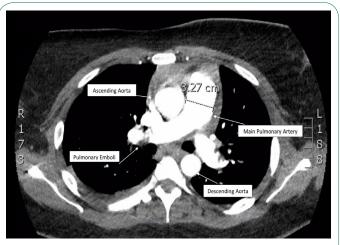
CT chest angiogram confirmed diagnosis of PE extending into all 5 lobes and 3.2 cm dilation of the pulmonary artery.
